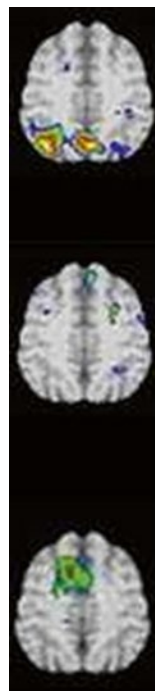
Following age regression, SVM based subtraction (horizontal orientation) images (of patient data from a psychiatrically screened relational PET ^{18}F -FDG database) shown at a horizontal digital slice of $z=40$ mm (Talairach & Tournoux coordinates, 1988) for 3 different individuals, each diagnostically classified as having Minimal Cognitive Impairment, but exhibiting very different cerebral activation patterns at rest. These images follow the radiological convention of viewing the patient’s brain from the foot of the patient’s bed so the right side of the brain images appears on the left side of the brain image. Correspondingly, the left side of the brain images are shown on the viewer’s right. This figure is adapted from Pardo et al. (1) Copyright (2010) with permission from Elsevier.
